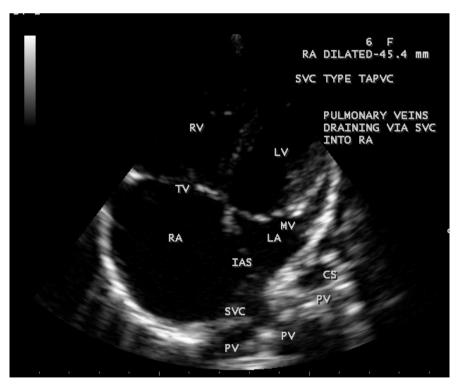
SVC (superior vena cava) type total anamolous pulmonary venous connection (TAPVC)—Apical four chamber view in a 6-year old girl. Right atrium (RA) dilated—45.4 mm.
